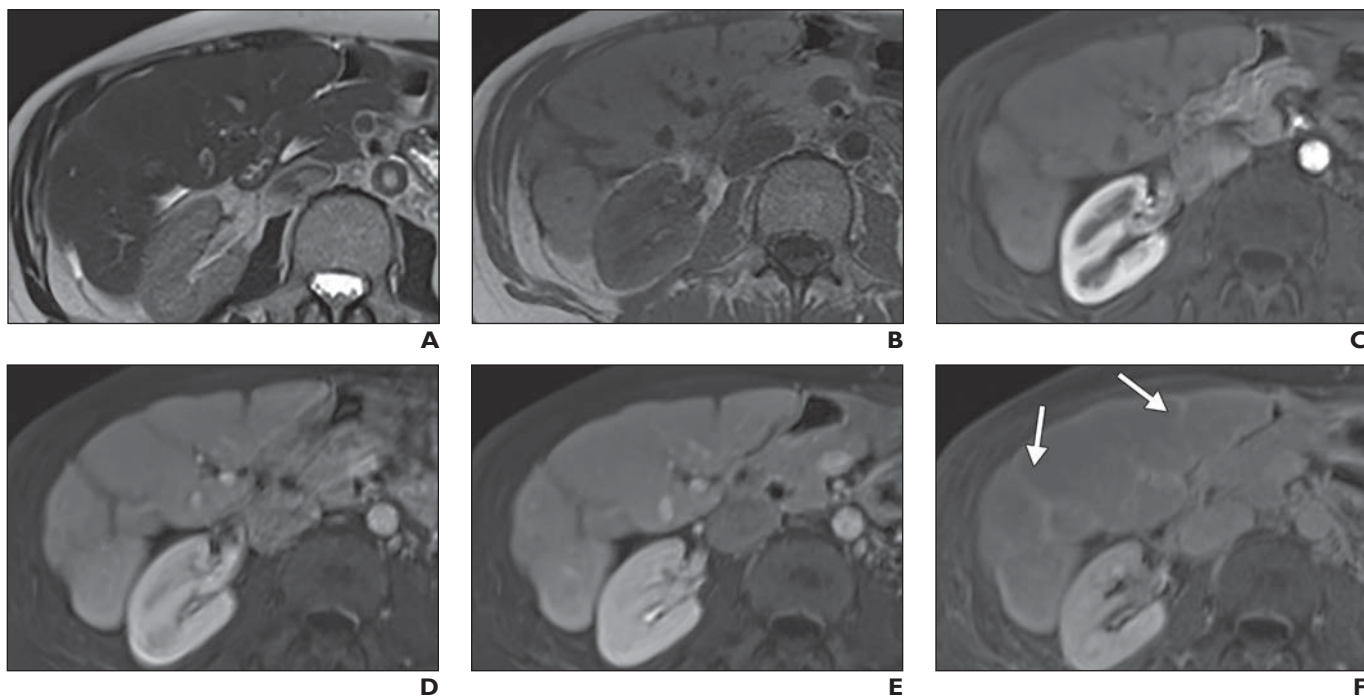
48-year-old woman with cirrhosis for 12 years. Example of focal scar. Bandlike areas of increased signal intensity are present on T2-weighted and decreased signal intensity on T1-weighted image with delayed phase enhancement (arrows, F). This is typical of focal scar and fibrosis. Areas of capsular retraction and volume loss accompany this finding.
